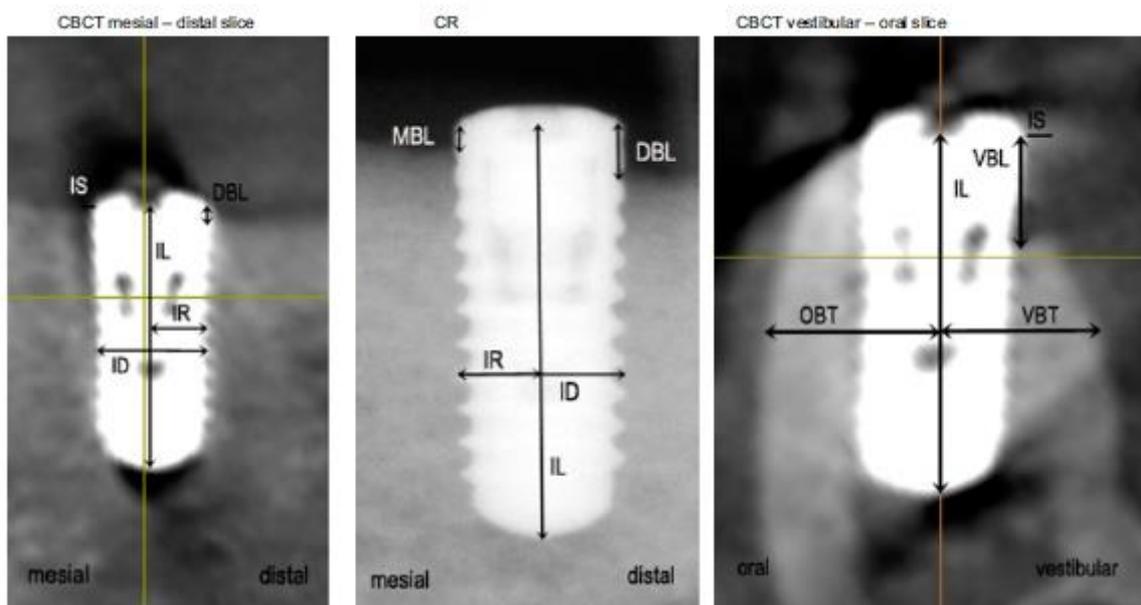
Data preparation of cone beam CT (CBCT) slices. DBL, distal bone level MBL, mesial bone level.
